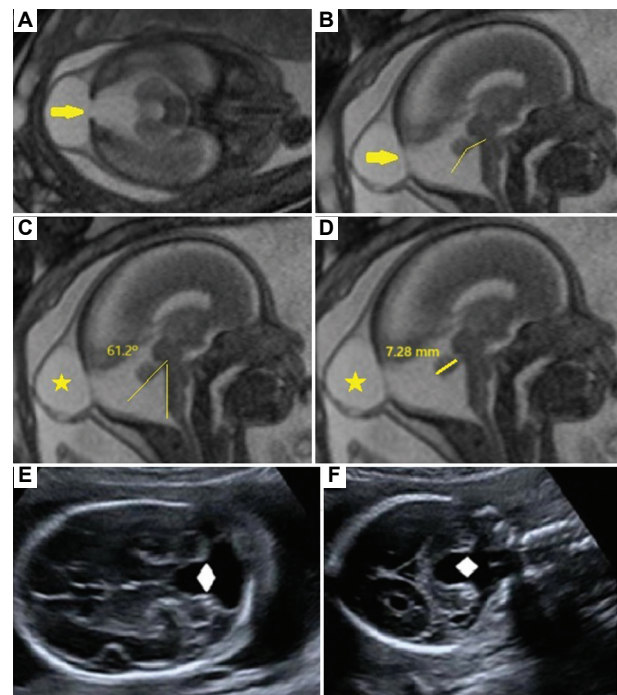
MRI and ultrasound images of different 21-week fetuses. (A–D) Axial TRUFI and sagittal HASTE images show DWM associated with an occipital bone defect-related (yellow arrow) encephalocele (yellow star). The images show vermian hypoplasia, an enlarged tegmentovermian angle, and an obtuse fastigial recess (thin line angle). (E and F) Axial and coronal ultrasound images show the fourth ventricle in relation to the cisterna magna, exhibiting cystic enlargement (white rhombus shape). Abbreviations: TRUFI: True fast imaging with steady-state precession; HASTE: Half-Fourier acquisition single-shot turbo spin-echo; DWM: Dandy–Walker malformation.
